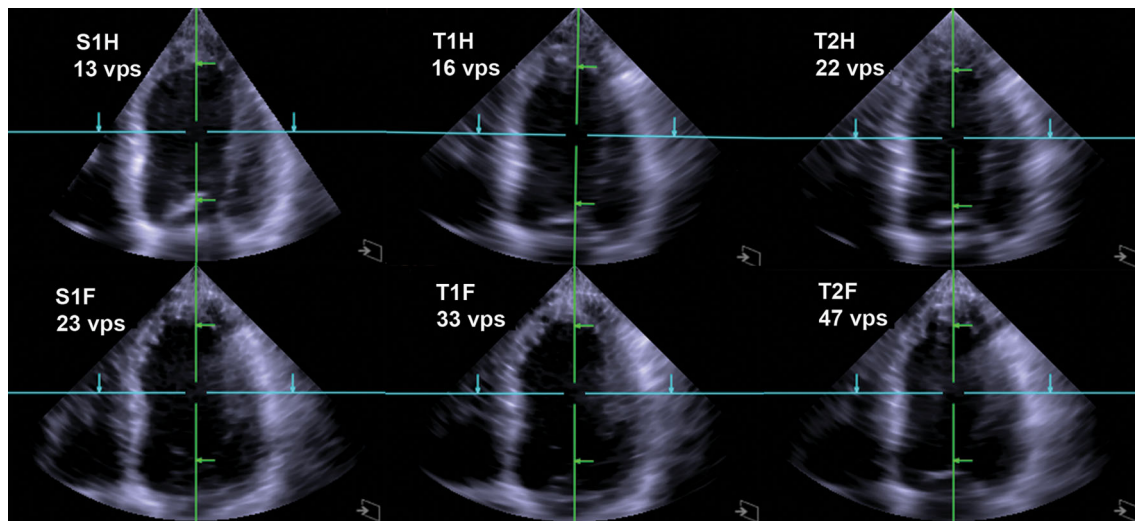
Sample 3DE datasets acquired by the six imaging modes with different temporal and spatial resolutions of Siemens single-beat full volume real-time 3D transthoracic echocardiography. *S1H* Space 1
